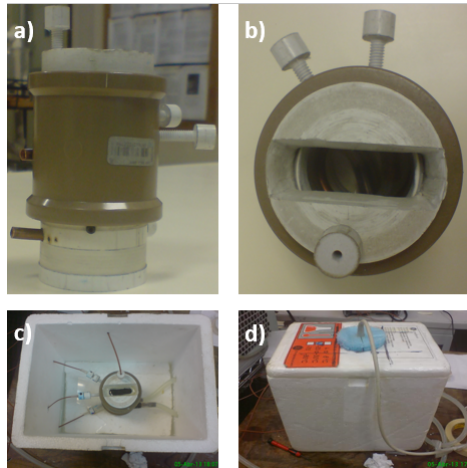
Photographies of the experimental setup developed for the temperature change based on the circulation of water by a copper coil. The PVC chamber is presented in lateral view (a) and top view (b). The top view of the opened polystyrene box is presented in c) where it is possible to observe the thermocouples connected. In d) it is presented the polystyrene box closed where its cover is used, also, to sustain the ultrasound transducer.
